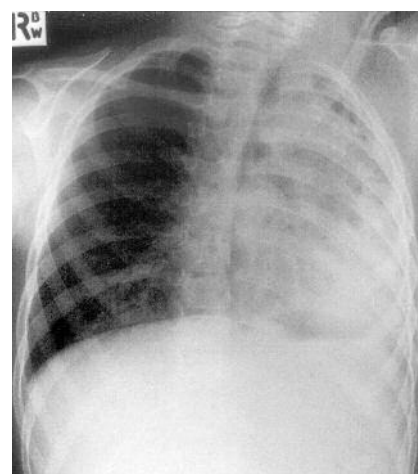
Typical chest x-ray of child with a retained foreign body in the left lung, which is totally collapsed. A large grass seed plus extensive granulation tissue were removed. The patient had experienced fever, cough and sputum production for many months.
